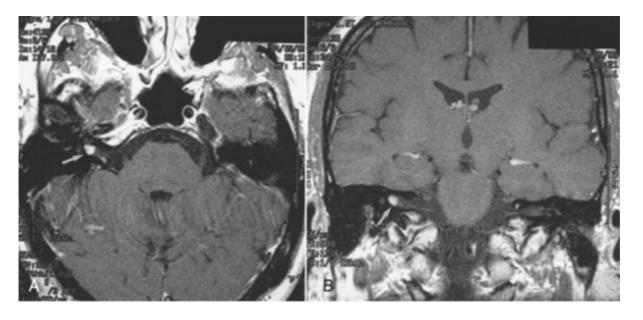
T1-weighted contrast-enhanced axial (A) and coronal (B) magnetic resonance imaging scans. Note the right inferior vestibular nerve schwannoma (*arrows*) located in the posteroinferior fundus of the internal auditory canal (IAC).
